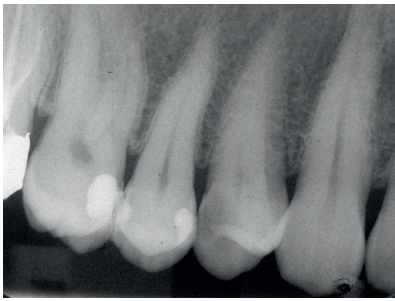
Radiograph revealed signs of an approximal carious lesion distally on tooth 14.
